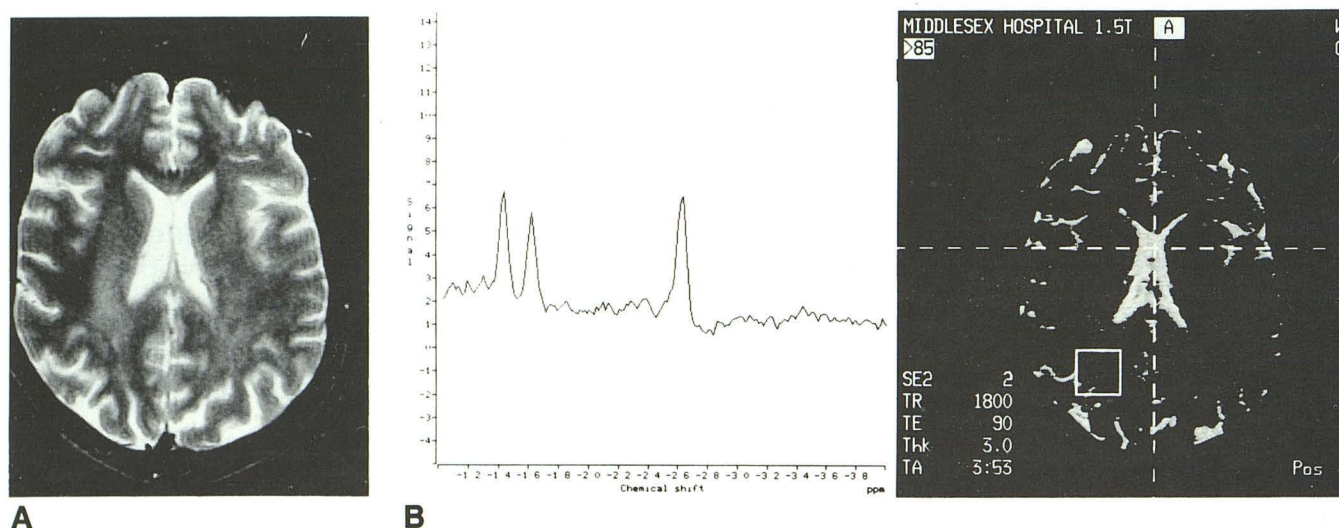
A, T2-weighted image (3500/90) of a 40-year-old patient with moderately severe cerebral atrophy and few white-matter changes.
